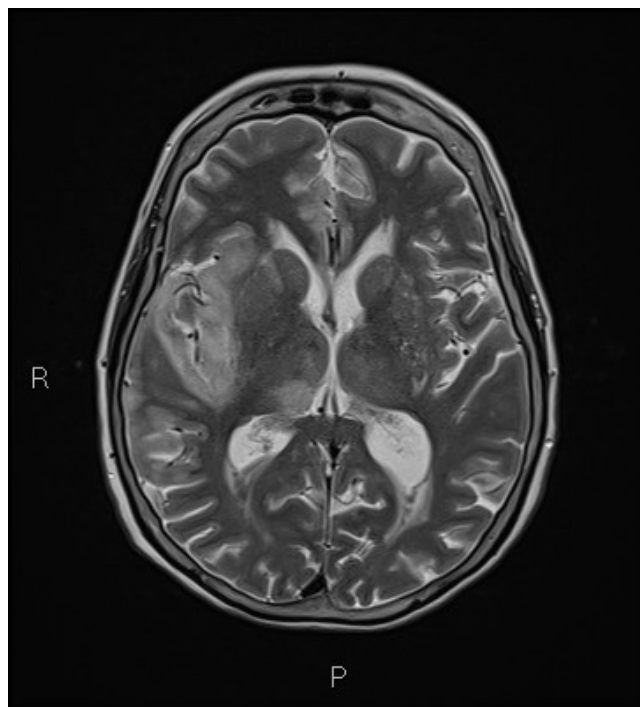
Magnetic Resonance Imaging (MRI) demonstrating generalized oedematous changes of the right temporal lobe with moderate intensity restricted diffusion seen involving the gyri of the right temporal lobe and right insular regions.
